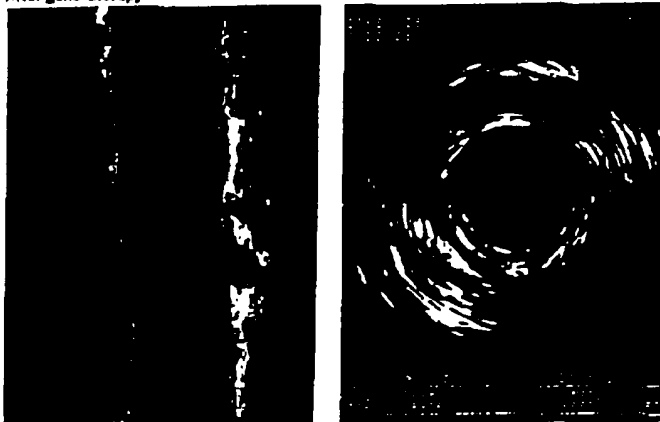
Three-dimensional reconstructions of entire length of gene-transfer site. Top=before, and bottom=after arterial gene transfer. Uniform luminal calibre is preserved, with pristine, three-layer appearance of arterial wall with no intimal thickening. I=intima, M=media, \*ultrasound catheter.
